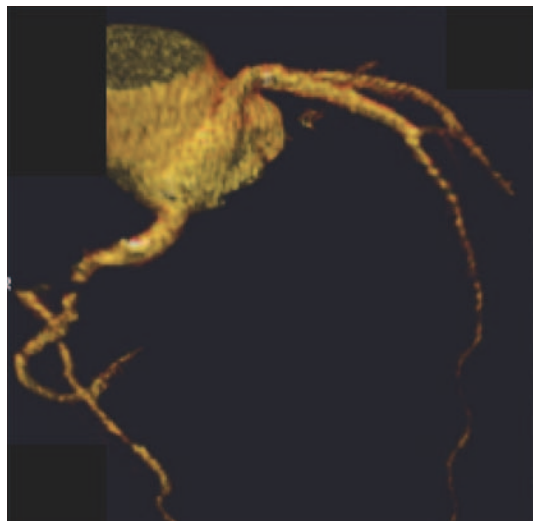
Computed tomography angiogram demonstrating an anomalous left main coronary artery arising from the right aortic sinus of Valsalva at an acute angle.
